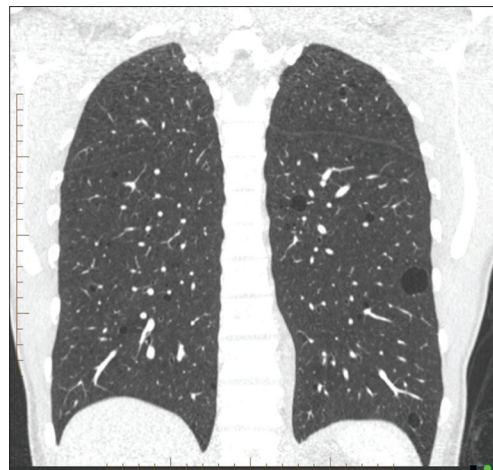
Computed tomography chest lung window coronal reformatted image in 2014 showed interval increase in the number of bilateral thin-walled cysts; the patient was asymptomatic
